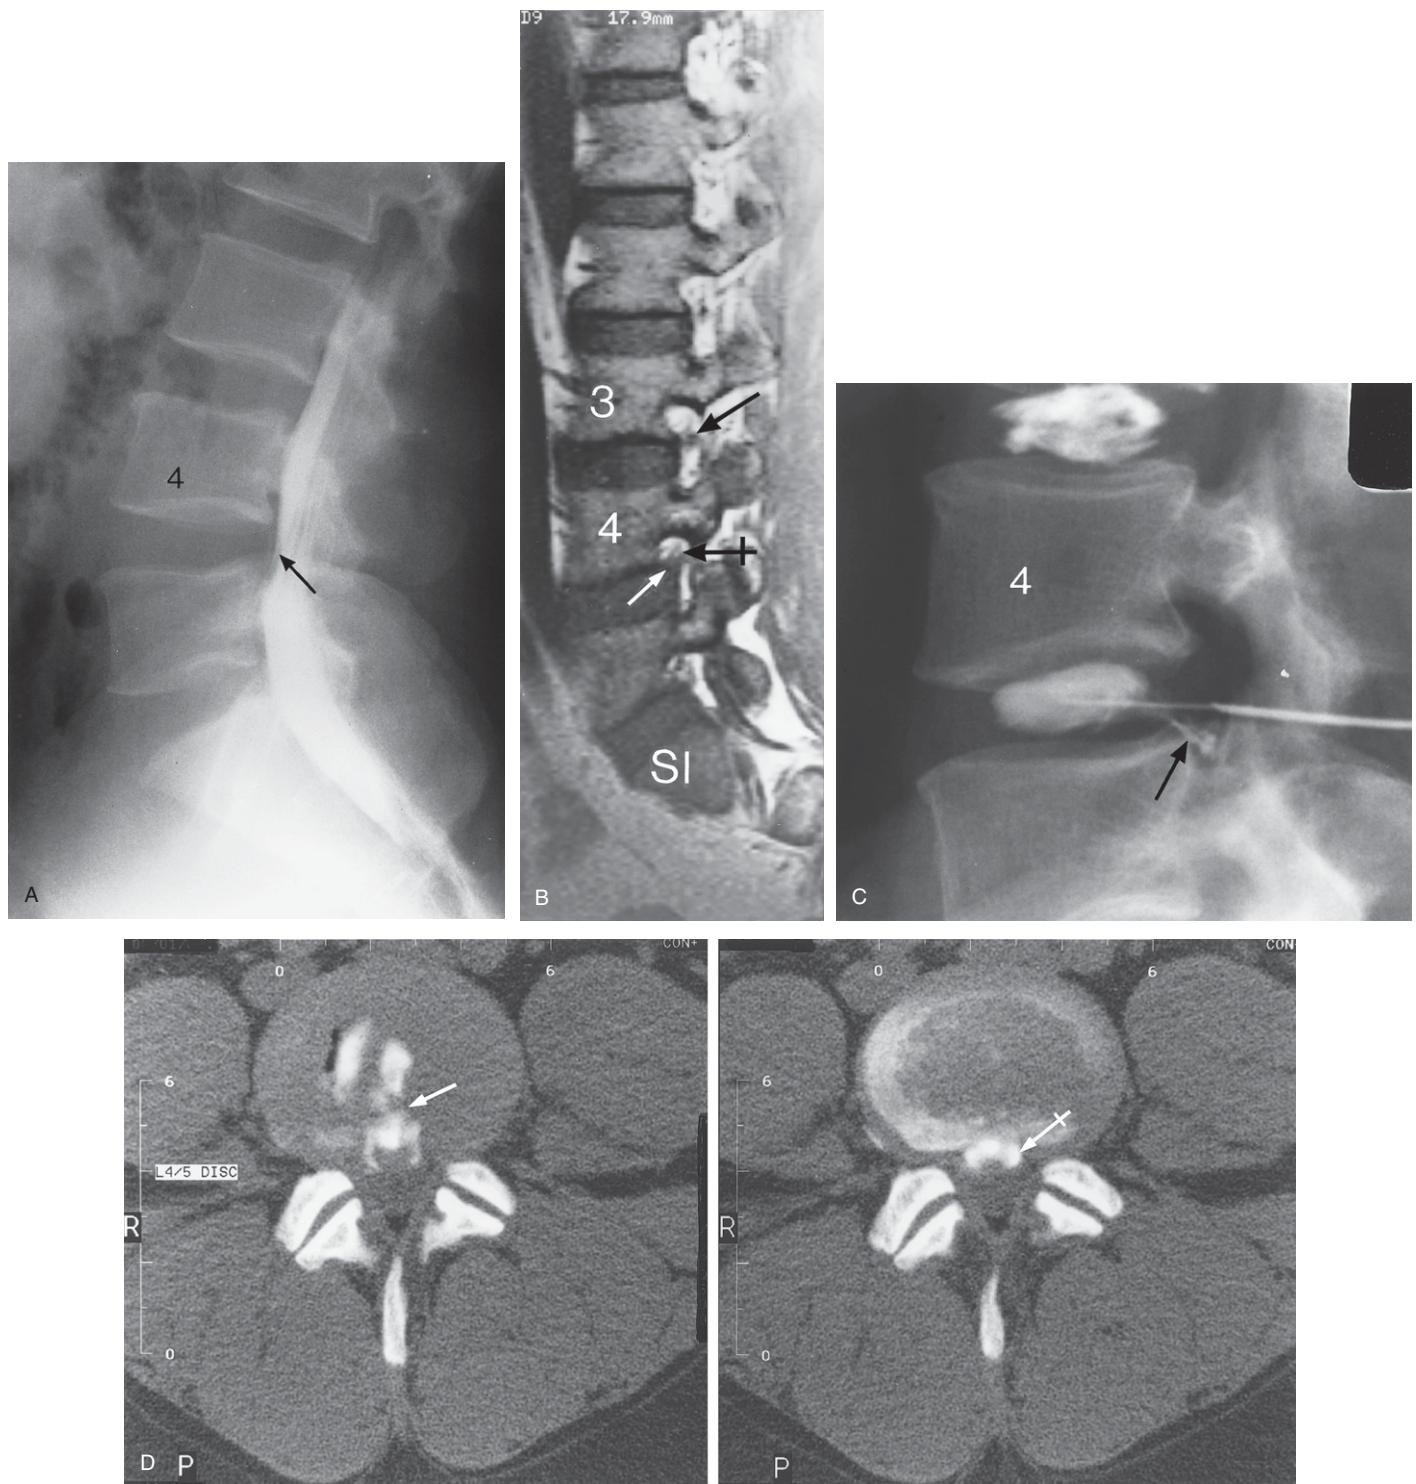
(A) Lateral lumbar spine myelogram contrast image showing some indentation of the thecal sac at the L4–5 level (arrow). (B) Lumbar spine MRI parasagittal T1-weighted image showing a normal intervertebral foramen at the L3–4 level with normal neural structures in the foramen (black arrow). Note the encroachment of disc material into the left L4–5 foramen (white arrow) with some pressure upon the nerve root at this level (tailed black arrow). Note how the disc material extends into the lower part of the intervertebral foramen narrowing its anteroposterior dimension considerably when compared with the L3–4 foramen. The nerve root at the L5–S1 disc level is normal, and lies within a normal intervertebral foramen. S1 = first sacral segment. (C) Lateral lumbar spine image of the discogram procedure at the L3–4 and L4–5 disc levels; at the L4–5 level, leakage of contrast material posteriorly is noted (arrow). (D) CT axial post-discogram images of the contrast in the L4–5 disc. This shows some internal disc disruption (white arrow) with posterior leakage of contrast material (tailed arrow) with a full thickness tear of the posterior disc fibres and reproduction of his pain.
